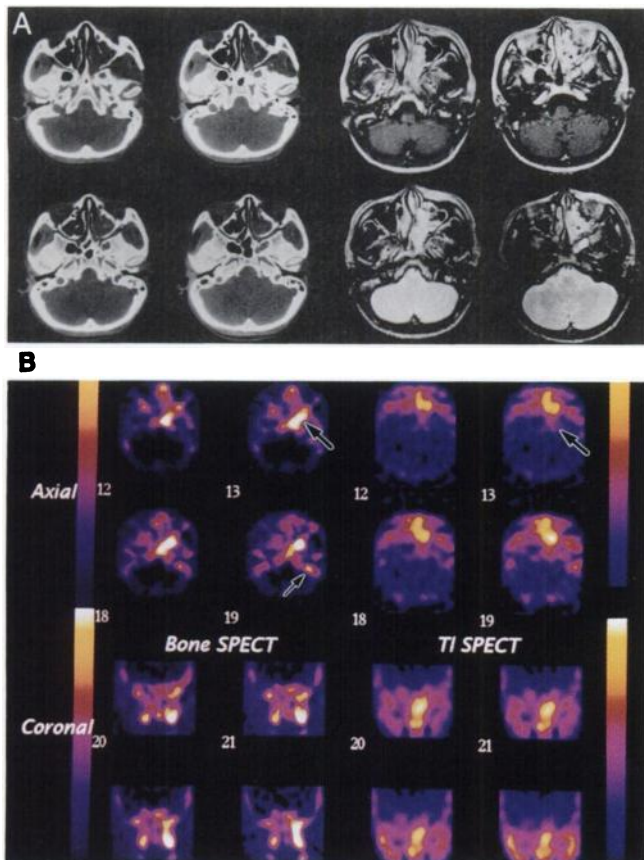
(A) CT and MRI scans from a 22-yr-old woman with nasal neuroblastoma were inconclusive for skull-base invasion. (B) S-SPECT revealed positive bone reactivity in the posterior nasal region with some tumor invasion (large arrows). A small accumulation of tracer was visualized in the right temporal bone in the bone SPECT image (small arrow).
